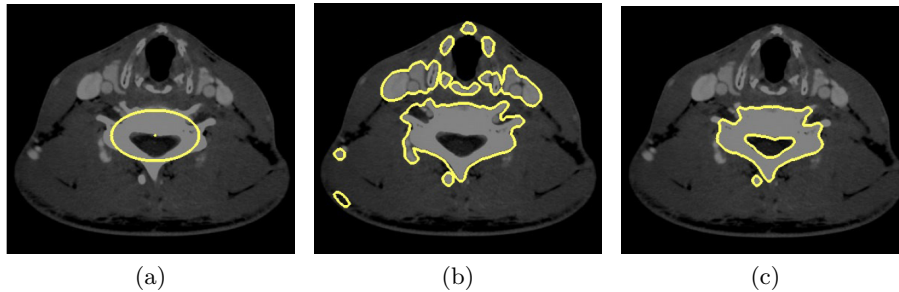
CT segmentation (b) without and (c) with moments constraints. The area constraint limits the segmentation to the size of the ellipse that was clicked by the user (a) that resulting in more accurate result. (Images adapted from [Klodt and Cremers, 2011] by permission)
